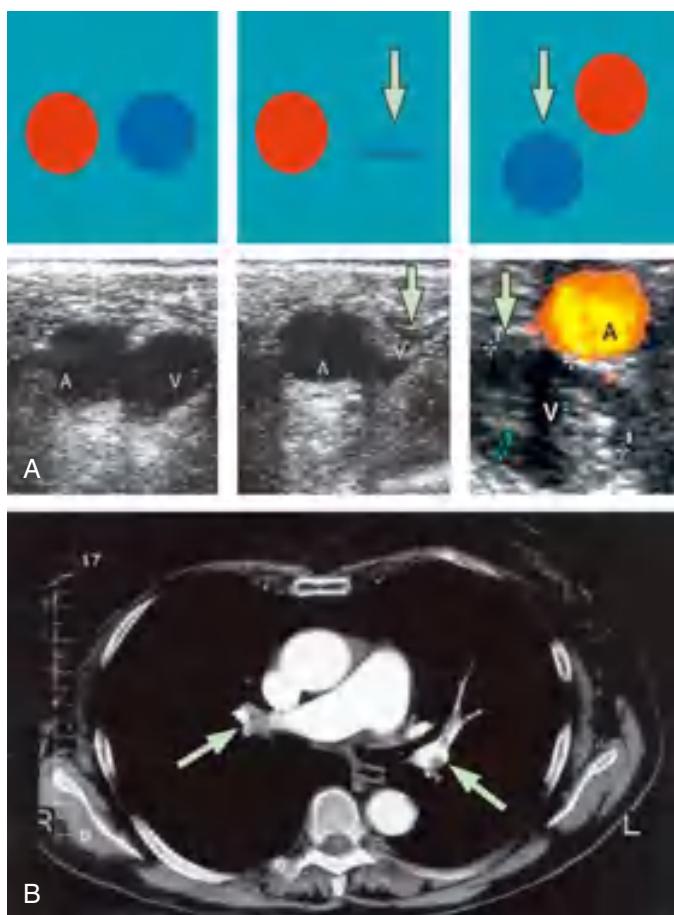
A, Compression ultrasound. Top images, from left to right, representation of vein and artery without and with (arrow) gentle compression with the echocardiographic probe. Bottom images, corresponding echocardiographic findings. The third image from the left shows a thrombus in the vein (vein not compressible by the probe). B, CT angiography showing several emboli (arrows) in the main right pulmonary artery and in left lobar and segmental arteries. A, Artery; V, vein. (From Goldhaber SZ, Bounameaux H. Pulmonary embolism and deep vein thrombosis. Lancet. 2012;379:1835–1844, Fig. 2, p. 1838.)
